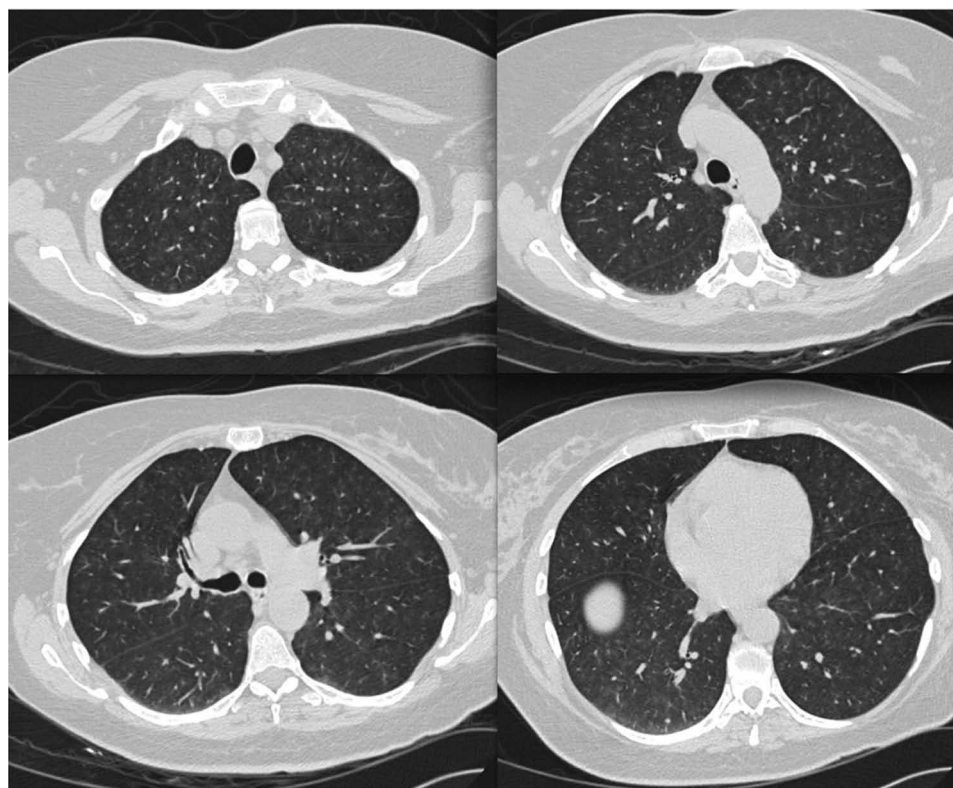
Chest CT scans showing diffuse ill-defined centrilobular nodularity.
